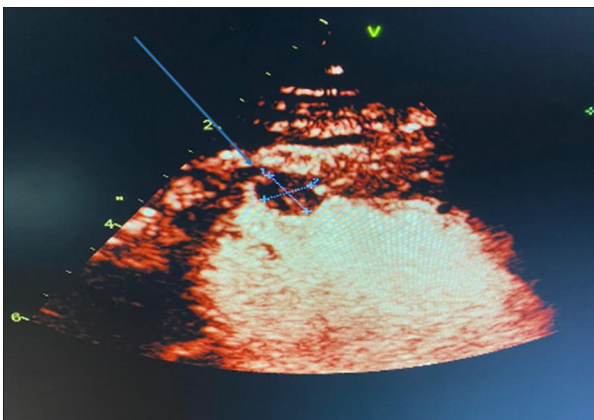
Echocardiogram showing left ventricular apical thrombus.
